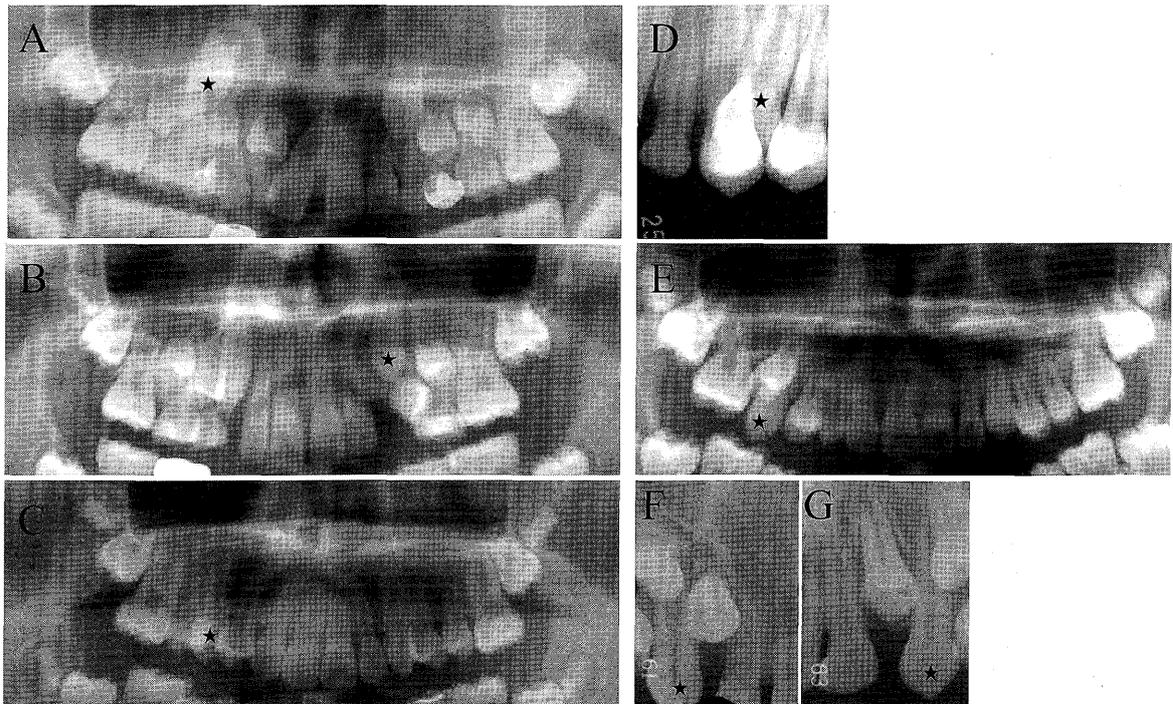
The initial x-ray photographs in Cases 1 to 6 of type A
